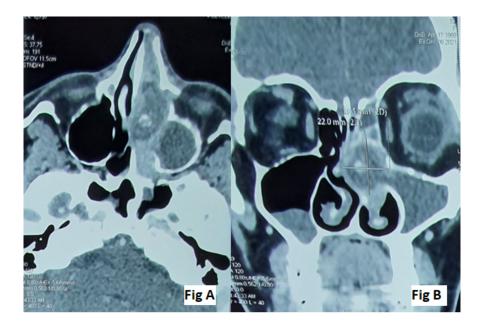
Axial (A) and coronal (B) PNS CT scan showing an hetergogenous left sided nasal mass attached to the medial turbiate with an ipsilateral maxillary and ethmoïd sinuses opacities
